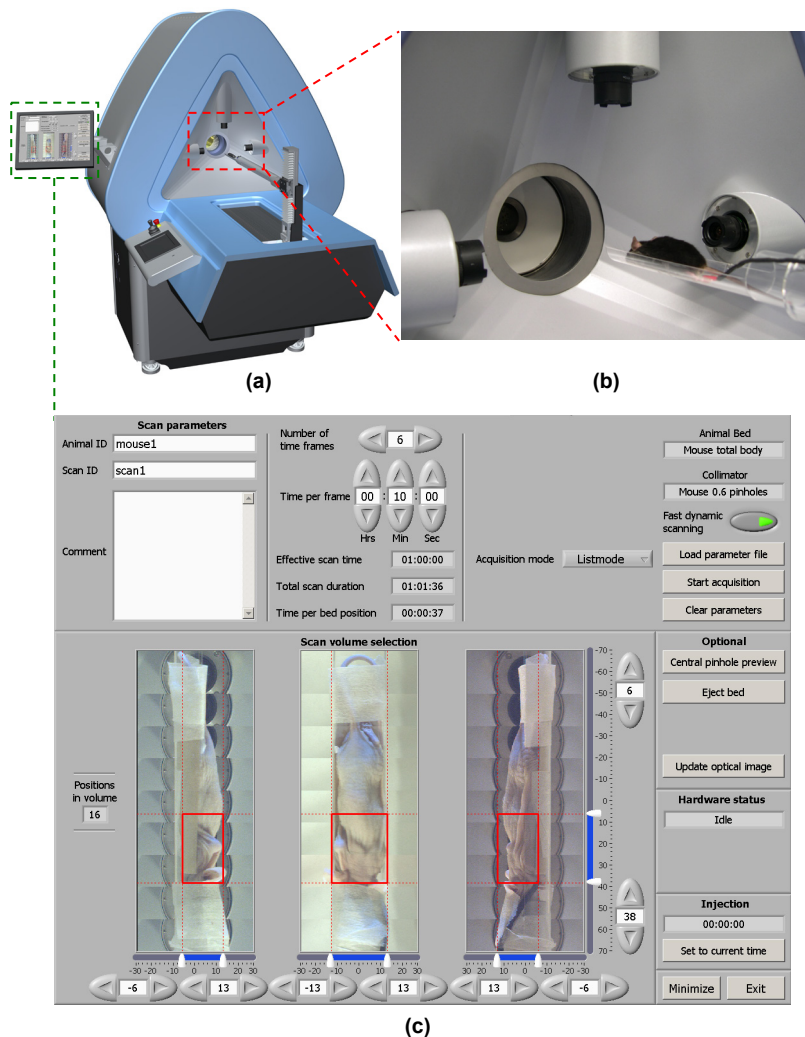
U-SPECT-II. (a) Overview of system. (b) Three integrated optical cameras. (c) User interface, showing optical photos for VOI selection.
